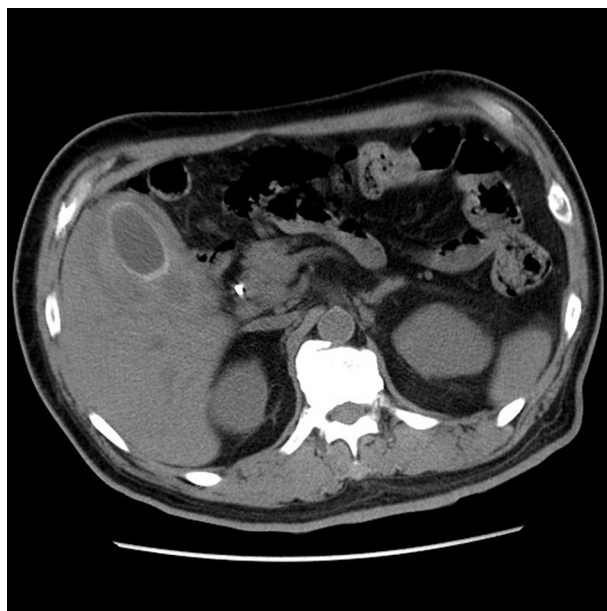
A noncontrast CT of the abdomen showing a hypodense lesion at the gallbladder neck.
